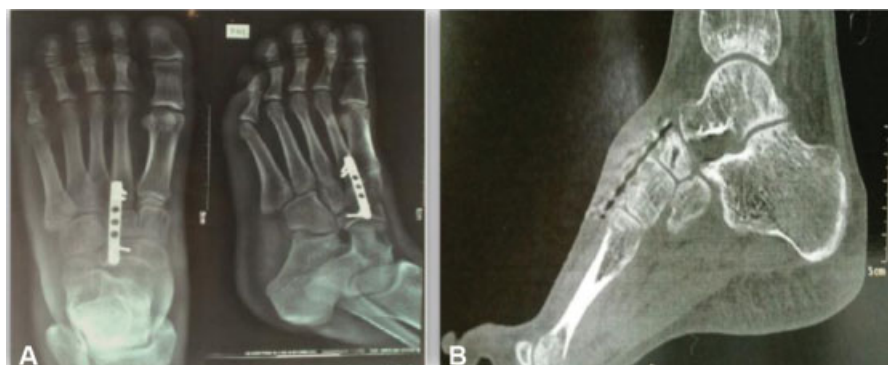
Imaging tests performed six months after surgery. We evidenced incorporation of the bone graft. (A) Radiography. (B) Computed tomography.
